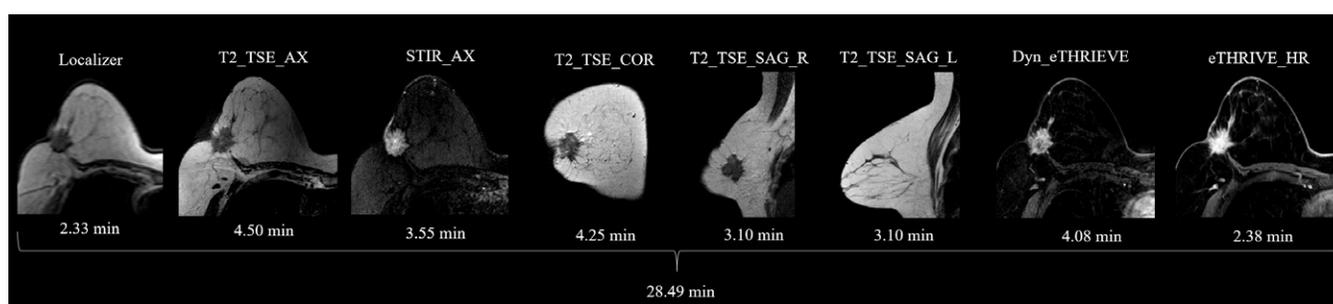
Contrast-Enhanced Breast MRI Protocol. The scanning sequence started with Localizer and morphological sequences, followed by 6 series of THRIVE dynamic scanning, concluding with a delayed high-resolution THRIVE series. The default overall scanning duration was 28.49 minutes; however, for larger breasts, the scanning duration could extend by up to 10 minutes.
